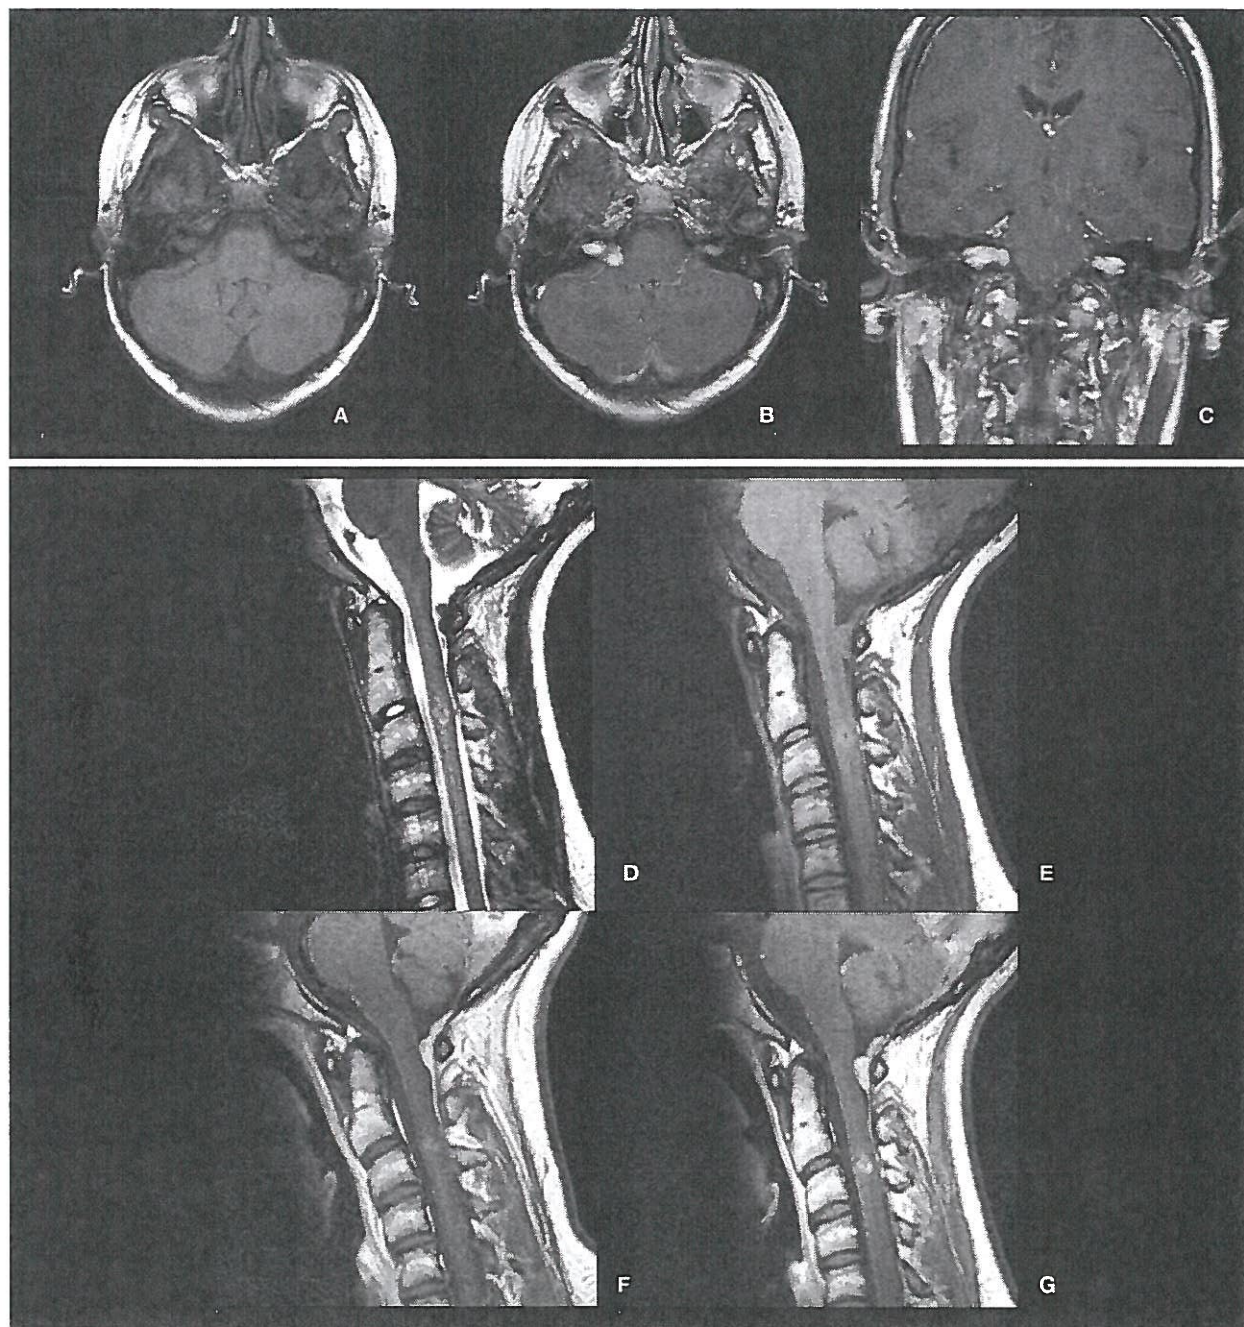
Neurofibromatosis type II diagnosed in 15-year-old girl with multiple cutaneous tumors and meningeal tumors. Technique: head coil, 1.5 T, Gd (gadopentetate dimeglumine or gadobutrol) by manual injection. Protocol: T2 TSE, T1, T1 Gd. Slice thickness 3–5 mm. Transverse (A, T1; B, T1 Gd), coronal (C, T1 Gd), and sagittal views (D, T2; E, T1; F and G, T1 Gd with gadopentetate dimeglumine and gadobutrol, respectively). Findings: Strong contrast enhancement in internal auditory canal. A high relaxivity agent (gadobutrol, 5 ml) showed strong enhancement in the cervical myelon (G vs. F). Conclusions: MRI assisted to diagnose schwannoma of the vestibular nerve at both hemispheres and also intraspinal neurofibroma. Notably, gadobutrol provided greater imaging efficacy than gadopentetate dimeglumine. Courtesy Professor H-J Mentzel.
